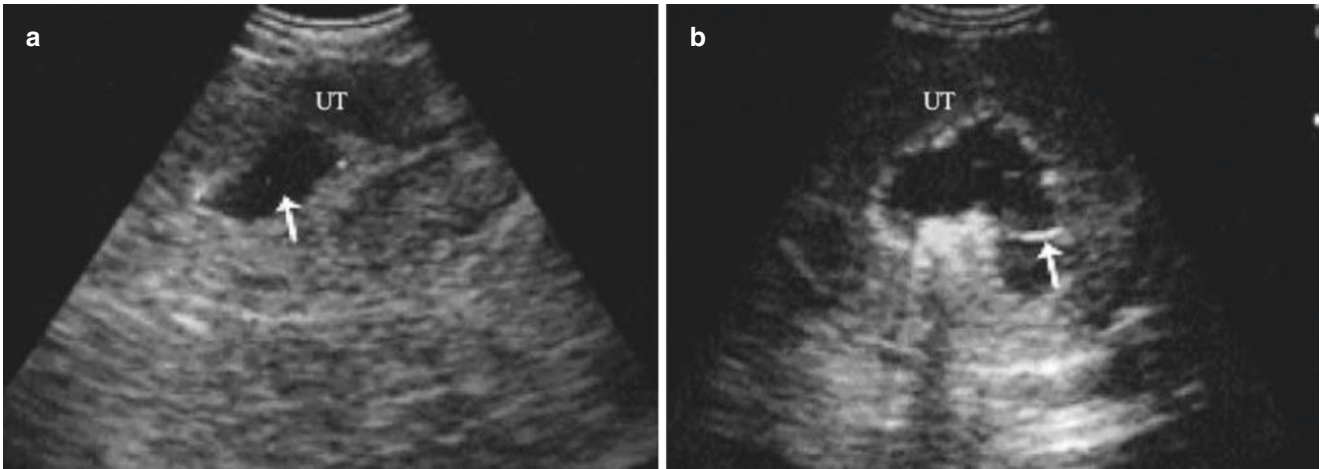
Sonohysterography of intrauterine adhesions. (a) The patient is 28 years old and has amenorrhea for three months after the abortion. Before the sonohysterography, ultrasound examination shows that a dark area of 2.1 cm × 2.5 cm × 1.4 cm in the uterine cavity; (b)
